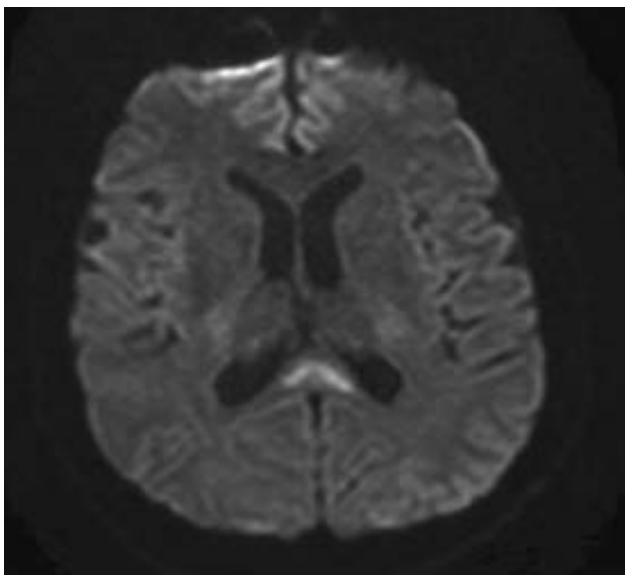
MRI of the brain, ADC/DWI – hyperintense lesions of the splenium of the corpus callosum: a) MRI of the brain, DWI; b) MRI of the brain, ADC.
